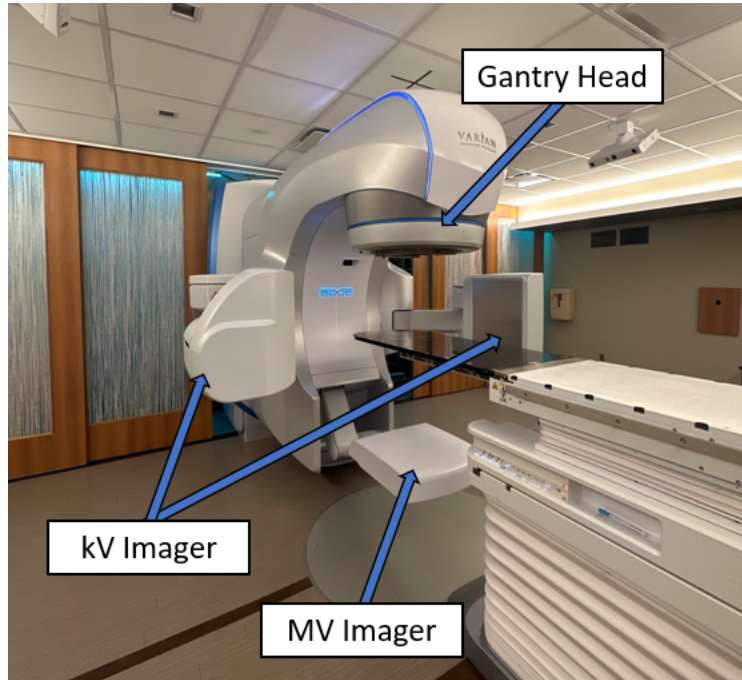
A Varian Edge linear accelerator at the University of Nebraska Medical Center (UNMC). Radiation is delivered via the gantry head to the patient positioned on the treatment table. The kV imager components are used to create cone-beam CT (CBCT) images which are used in this study. The MV imager can be used to capture a beam's-eye-view of the radiation field.
